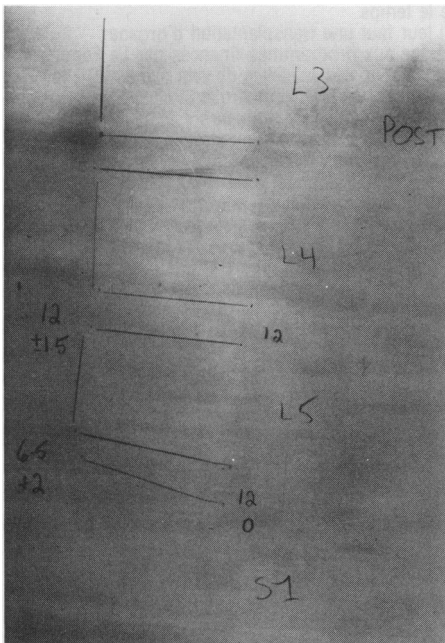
Patient #2. Post-Inversion radiograph.
